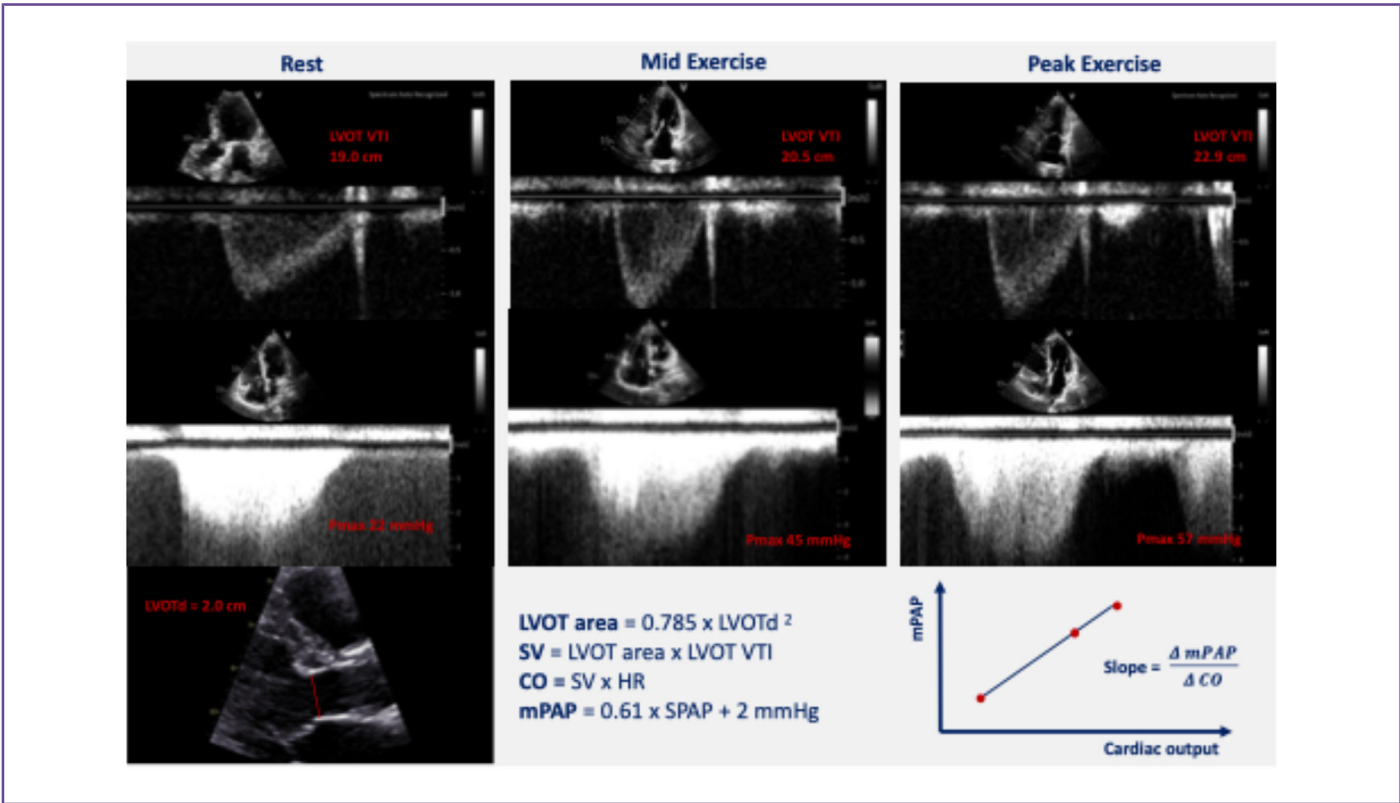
Noninvasive assessment of the mPAP/CO slope. A case example of exercise mPAP/CO slope calculation using echocardiographic and CPET data. CPET, CO, cardiac output; LVOT, left ventricular outflow tract; mPAP, mean pulmonary artery pressure; VTI, velocity time integral. (Used with the permission of Dhont et al.²⁷)
